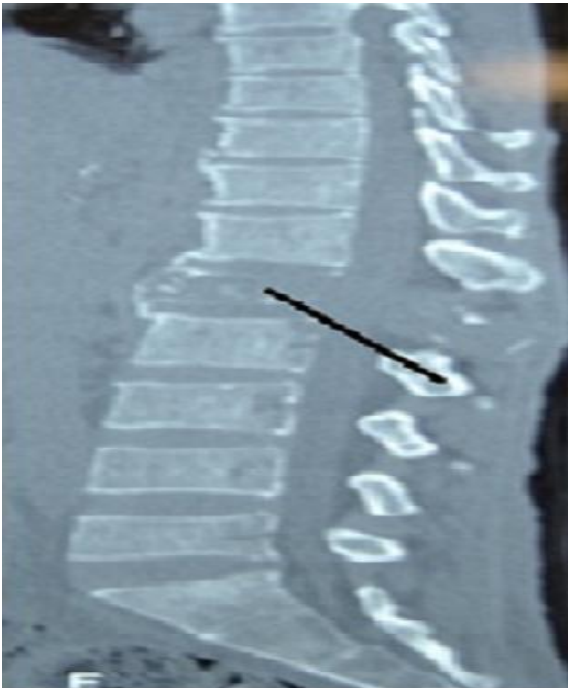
CT scan showing L1 osteolytic vertebra body lesions (black arrow) with a soft tissue swelling and L4 osteopenia sparing intervertebral disk spaces
